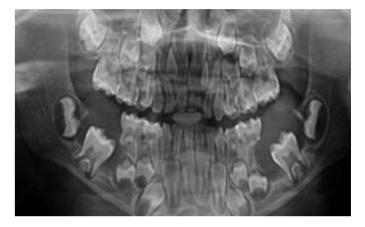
Panoramic radiograph showing pericoronal radiolucency on both right and left side.
